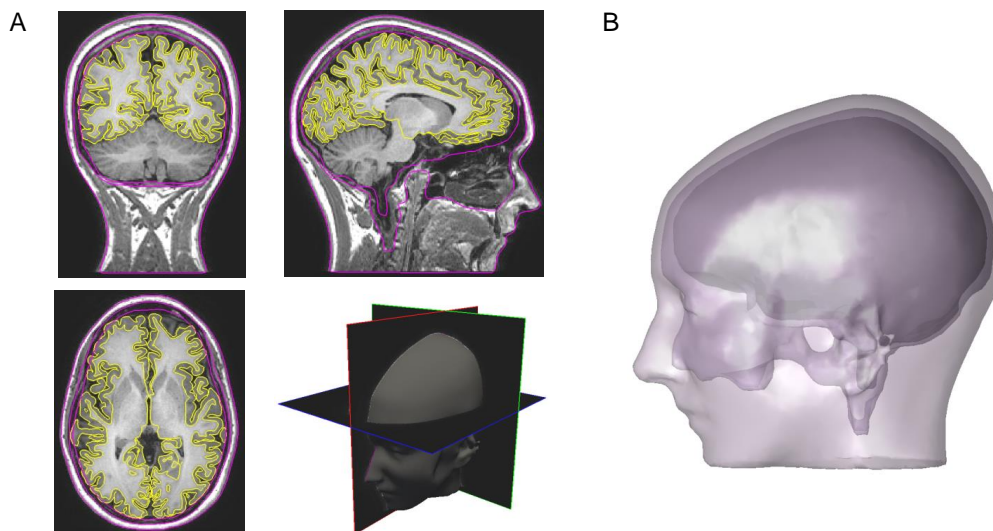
Boundary surfaces produced by MRI segmentation. A. Surfaces are overlaid into a subject's MRI. White matter and pial surfaces produced by Freesurfer software are displayed in yellow. Inner skull, outer skull and skin surfaces produced by NIFT software are represented in pink. B. 3D view of the inner skull, outer skull and scalp surfaces that can be used as input to the 3-shell BEM solution of the forward problem.
